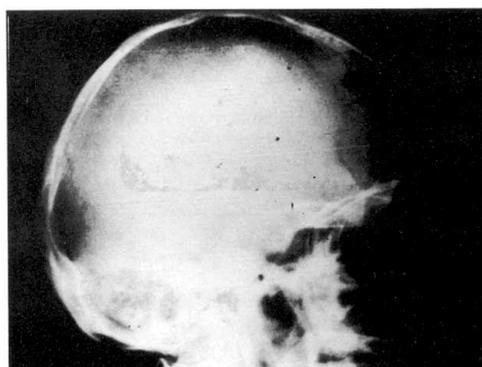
Lateral skull x-rays showing a hypodense eroded region in the frontal bone.
